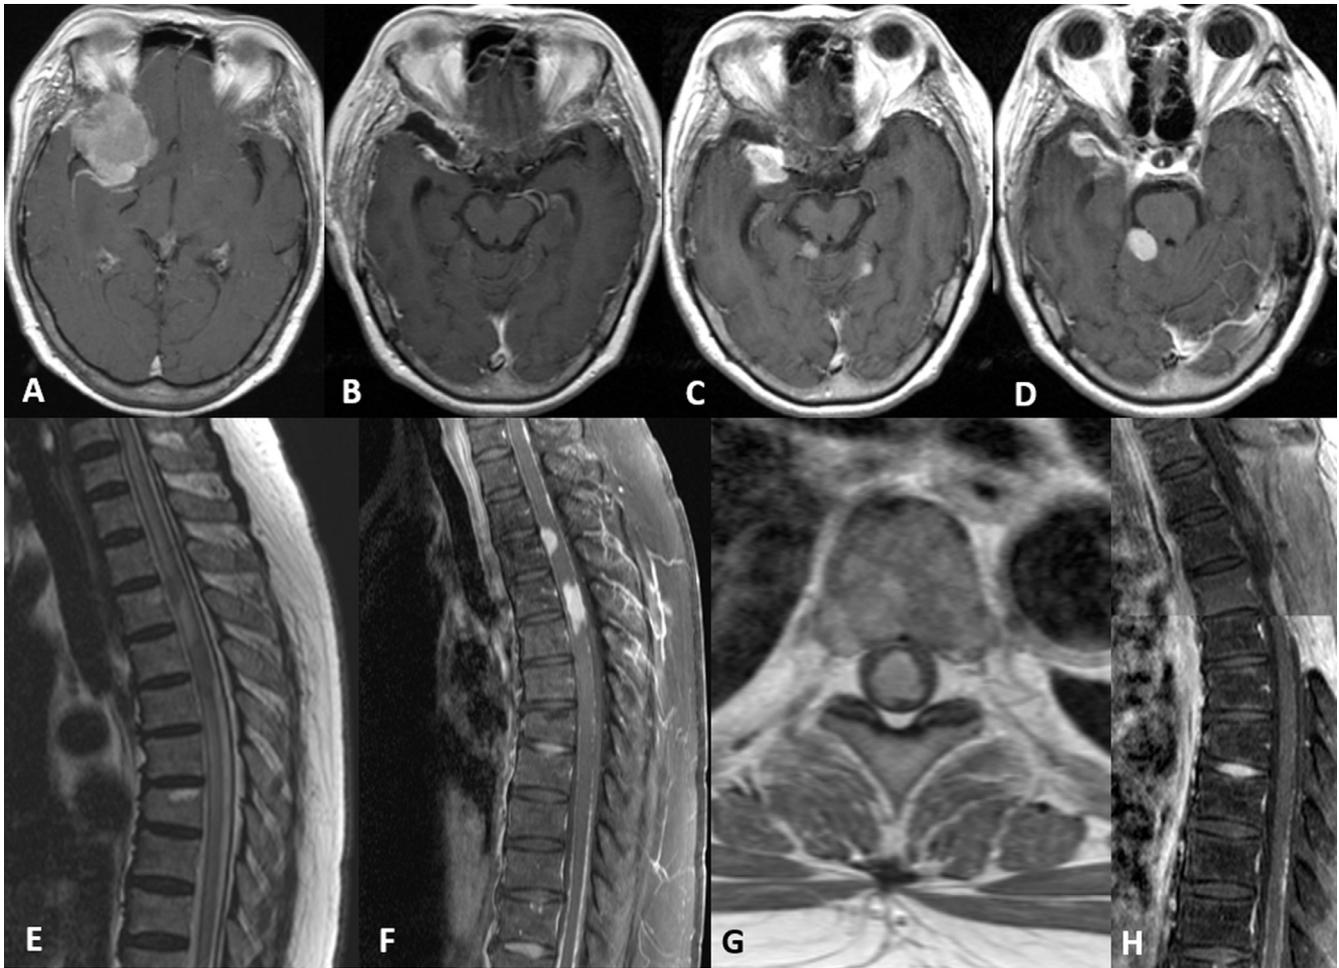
A patient with metastatic atypical spinal meningioma who underwent subtotal tumor removal. Brain MRI showed a tumor abutting the lesser wing of the sphenoid bone on the right side (A). The tumor was completely excised, as shown on postoperative MRI (B). Multiple meningiomas were found on MRI 18 months later (C and D). Spinal MRI revealed tumors at the T3-4 level with leptomeningeal seeding 2 years after the original surgery (E–G). The intramedullary spinal tumors at T3-4 underwent subtotal resection (H). MRI, magnetic resonance imaging.
